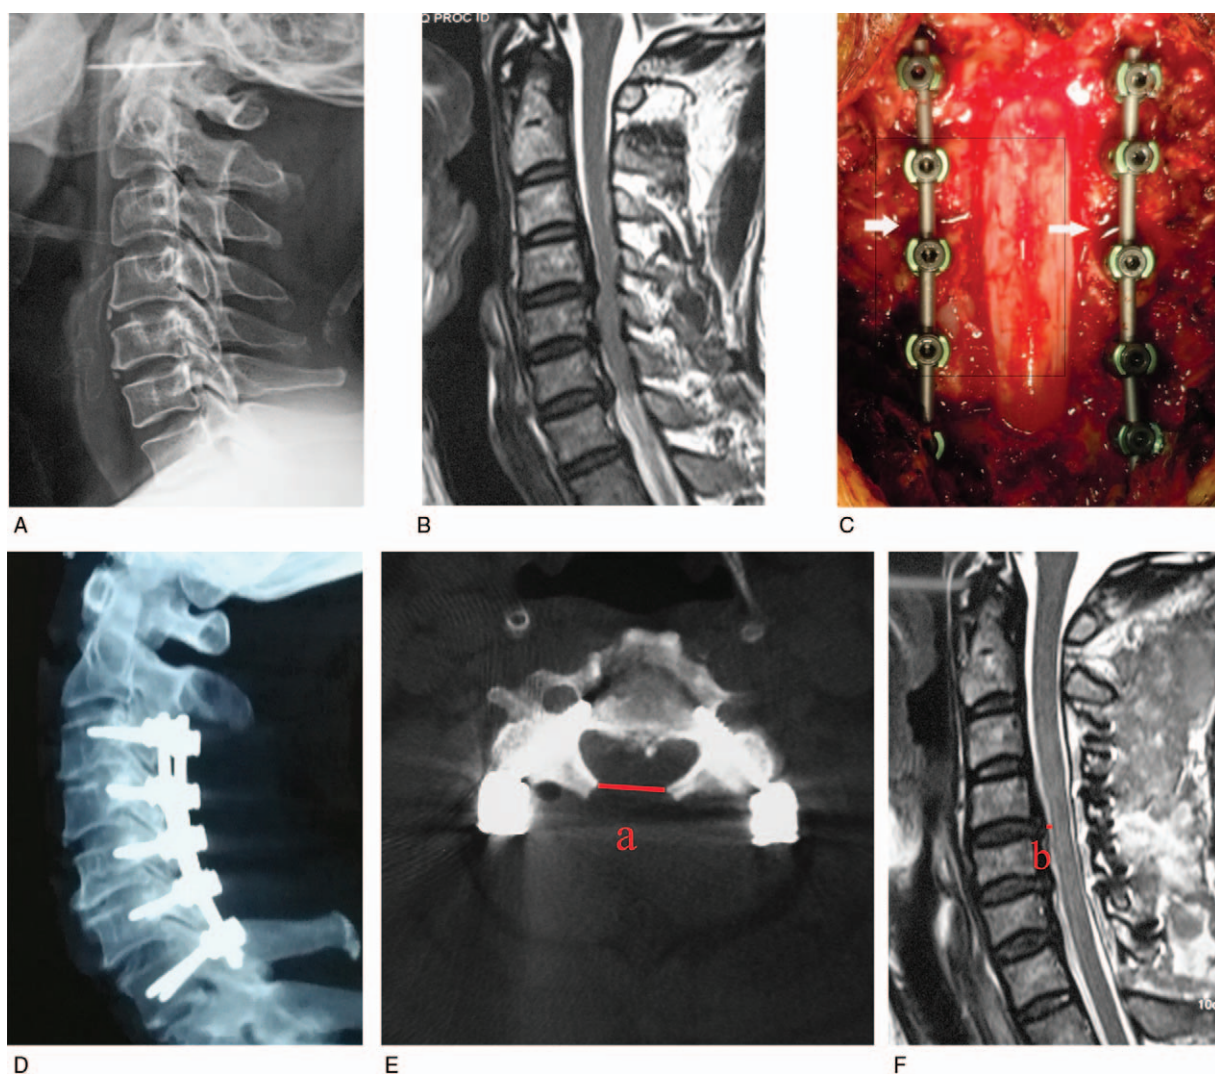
A 61-year-old woman with multi-segment cervical spondylotic myelopathy manifesting as a 21-month history of limb numbness and weakness. A: Preoperative X-ray showing cervical spine degeneration and the posterior longitudinal ligament ossification at the posterior vertebral edge. B: Spinal cord compression is evident in the C4–7 segments. C: The spinal cord was decompressed using limited laminectomy and foraminal decompression with fixation. D, E: Computed tomography scan confirming internal fixation position and a laminectomy width of 15.1 mm at C4 level. F: Magnetic resonance image taken 3 months postoperative showing adequate decompression of the spinal cord and a 2.1-mm drift distance at C5.
